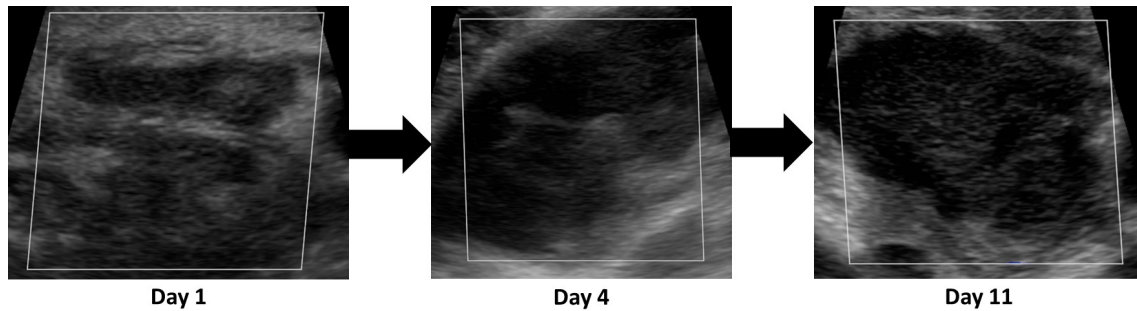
Ultrasound images taken on Day 1, Day 4 and Day 11 for case report #2
